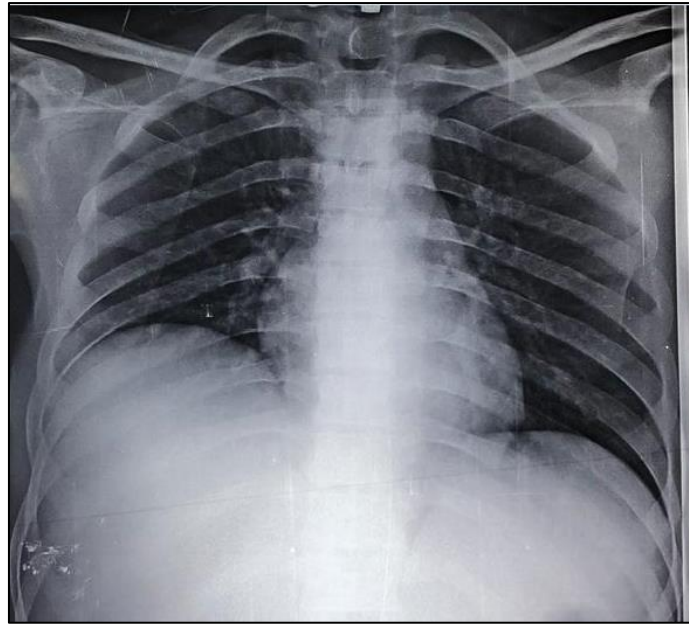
Chest X-Ray demonstrating an elevation of the right diaphragmatic dome
